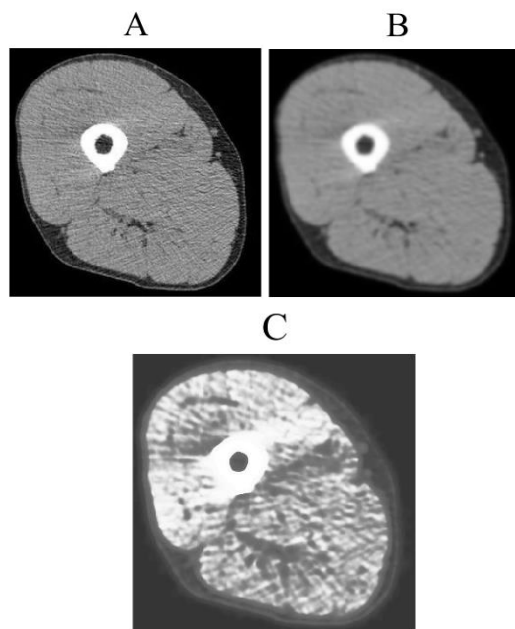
MRI image preprocessing effects
